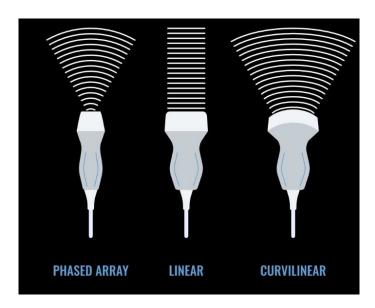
Ultrasound probes type
